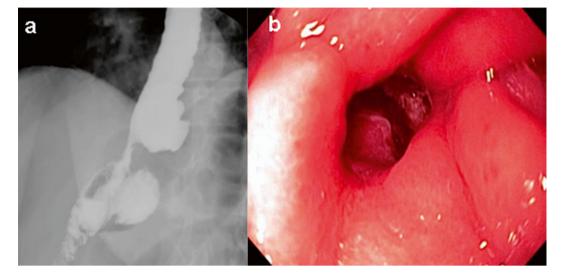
(a) Radiographic evidence of a stricture and (b) endoscopic appearance of stenosis after gastric bypass.
